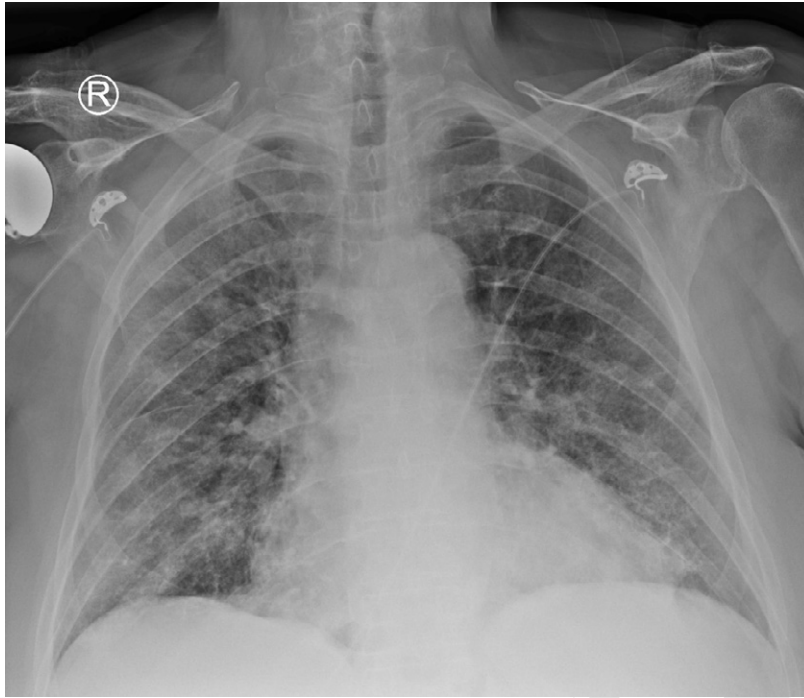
Examples of patients with coronavirus disease 2019 who did (i.e. required intubation and or died) and did not develop critical illness (i.e. did not need intubation and were discharged). A, Radiograph in an 80-year-old woman with 7 days of symptoms prior to emergency ward presentation. She had hypertension and chronic obstructive lung disease as comorbidity. Laboratory findings were as follows: neutrophil granulocytes $6.4 \times 10^9/L$, C-reactive protein 282 mg/L, lactate
